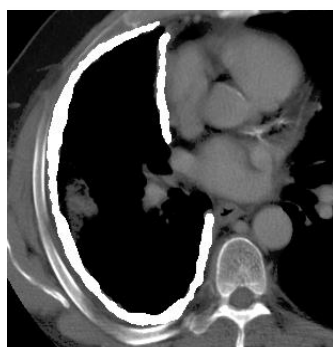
Left: Malignant pleural mesothelioma (MPM, white) shown superimposed on a lung CT image. Right: the thin, curved nature of the MPM is shown in a projection of the 3D volume (Chen and Brady, 2014).
